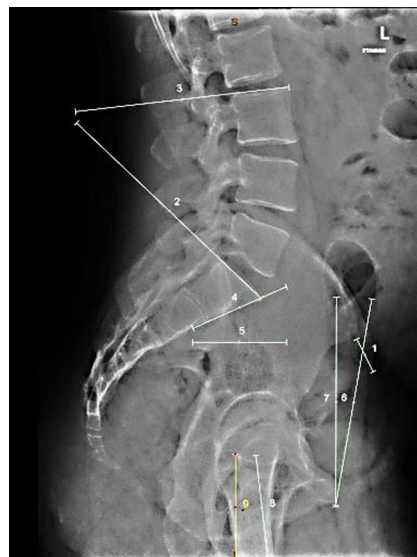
Angles measured from radiographs. a Cobb angle between L3 and S1 between lines 2 and 3. b Sacral inclination between inferior surface of sacrum and horizontal line (lines 4 and 5). c Pelvic tilt angle (lines 6 and 7) posterior tilt negative anterior tilt positive. d Femur flexion relative to the vertical axis (between lines 8 and 9)
